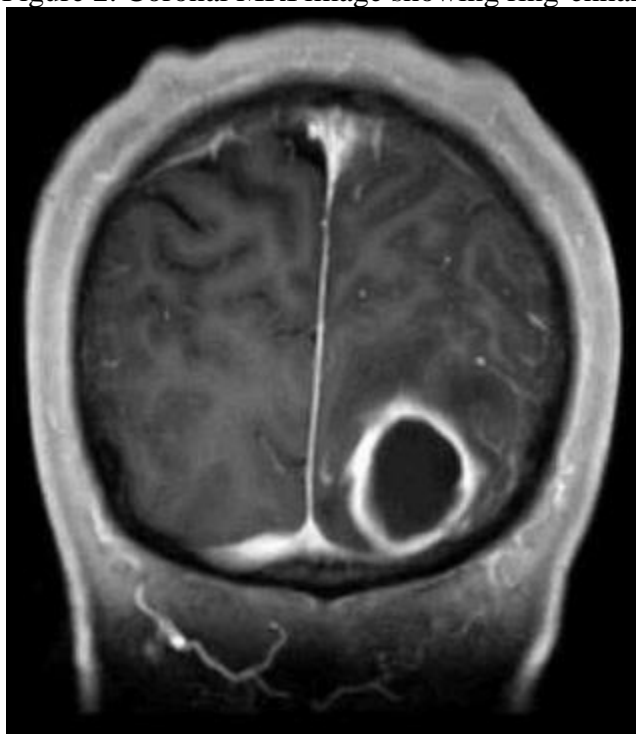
Coronal MRI image showing ring-enhancing lesion
